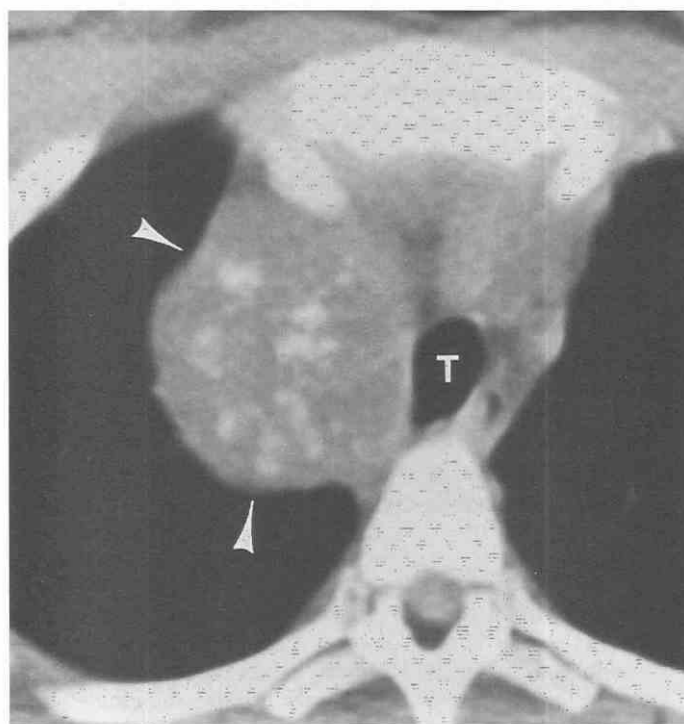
Mediastinal granuloma caused by histoplasmosis. CT shows soft-tissue-attenuation mass with punctate calcification (arrowheads) in the superior mediastinum. Biopsy confirmed histoplasmosis. T, trachea.
